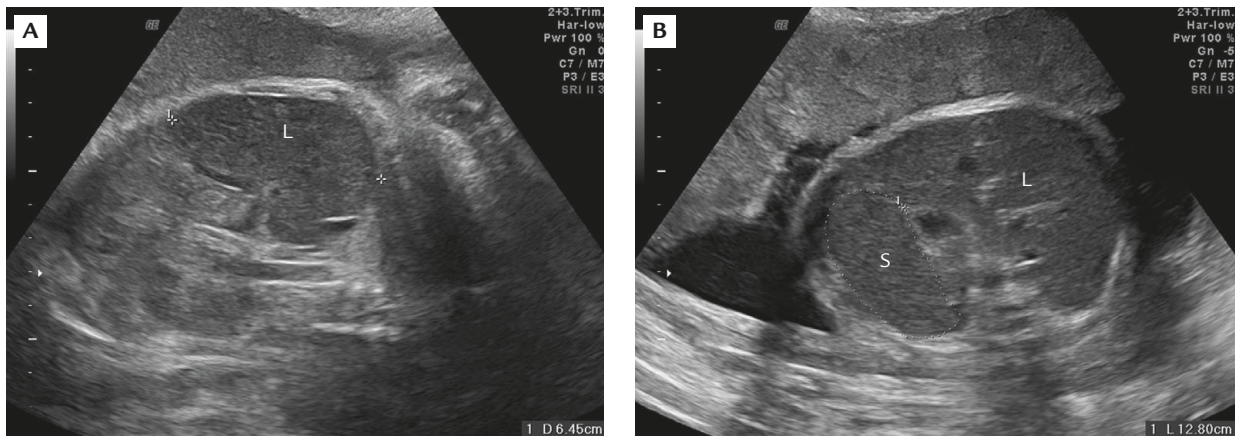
Prenatal ultrasound at 34 weeks' gestation shows: (A) hepatosplenomegaly in the longitudinal section, and (B) splenomegaly in the transverse section with resolution of fetal ascites. L=liver, S=spleen.
